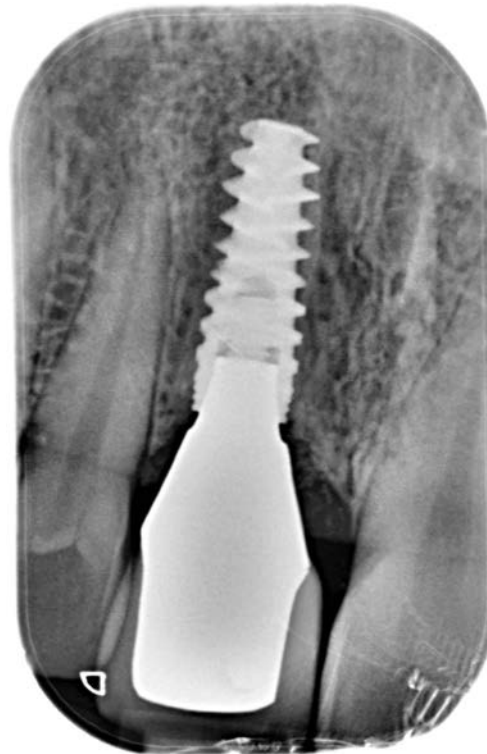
Postoperative periapical radiograph.
